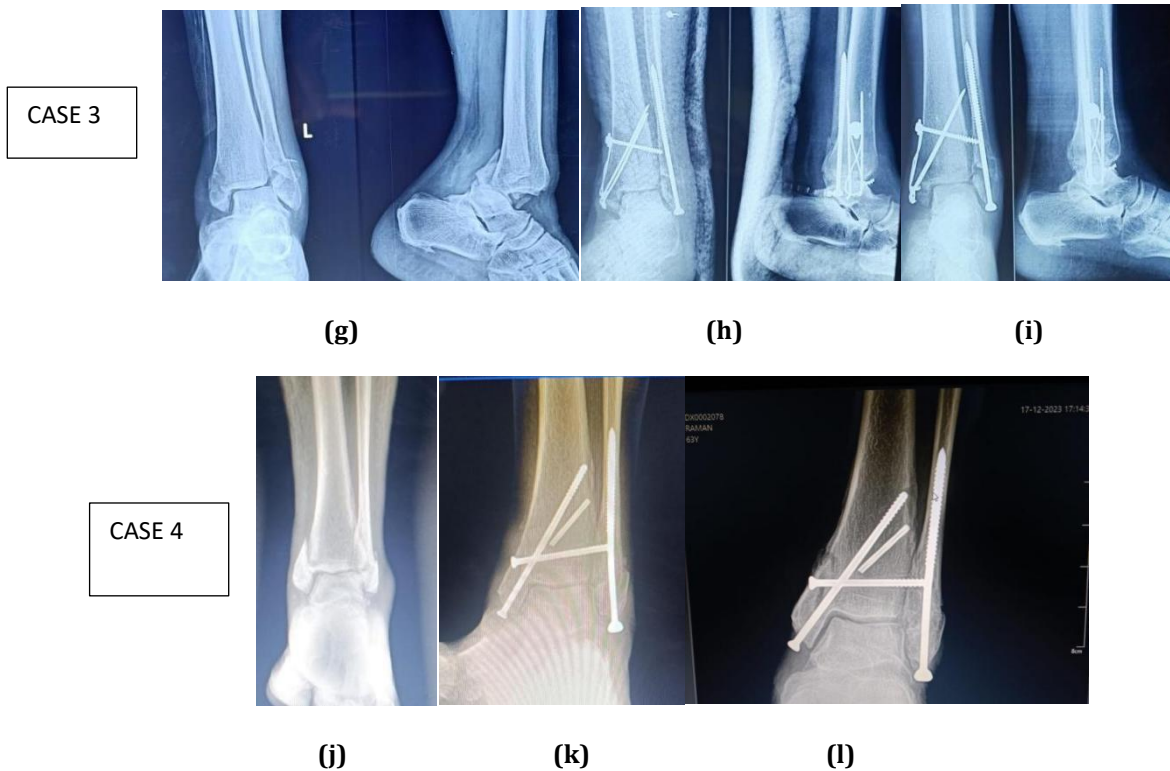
(a,d,g,j Pre-operative xrays), (b,e,h,k immediate post-operative xrays), (c,f,i,k Follow up xrays)
